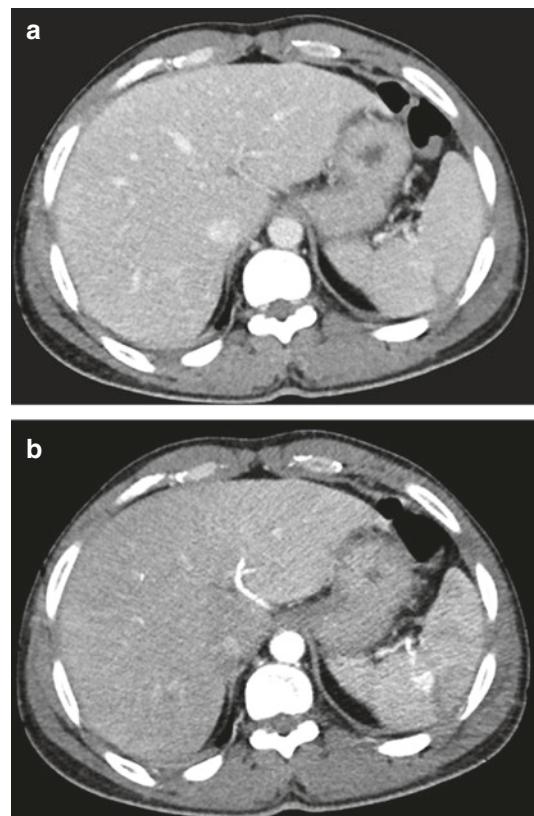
A 40-year-old man who underwent an initial single portal-phase MDCT protocol after a motor vehicle collision. IV contrast-enhanced CT image shows a small laceration in the spleen without significant free hemoperitoneum (a). Follow-up CT shows a well-defined, rounded splenic pseudoaneurysm in the arterial phase (b). In comparison, note that the pseudoaneurysm was faintly seen on the initial scan. Comment: this patient emphasizes the value of a dual-phase MDCT protocol in high-energy trauma and the importance of the arterial phase in the detection of traumatic pseudoaneurysms. Using a single-phase MDCT protocol, contained vascular injuries may be easily overlooked
